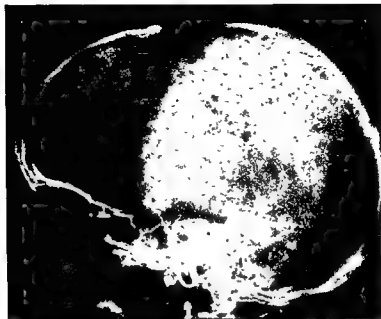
Roentgenogram of skull showing multiple small osteolytic lesions in a case of multiple myeloma.
